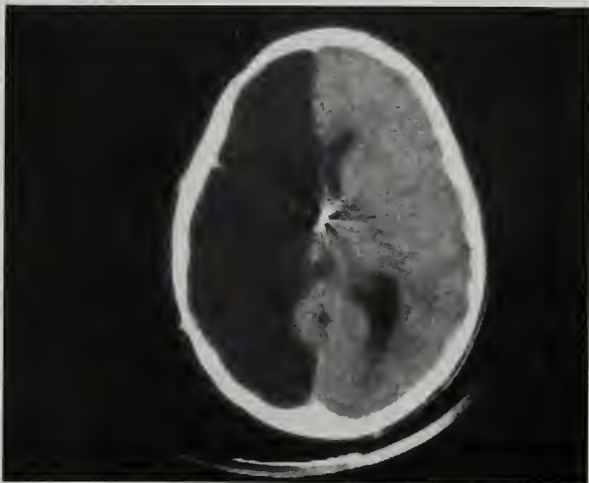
Head CT one year after right hemispherectomy done 12 and one-half years ago for intractable seizures (up to 10 episodes daily) and behavior disorder. Today high school graduate at age 19. On no medications.
